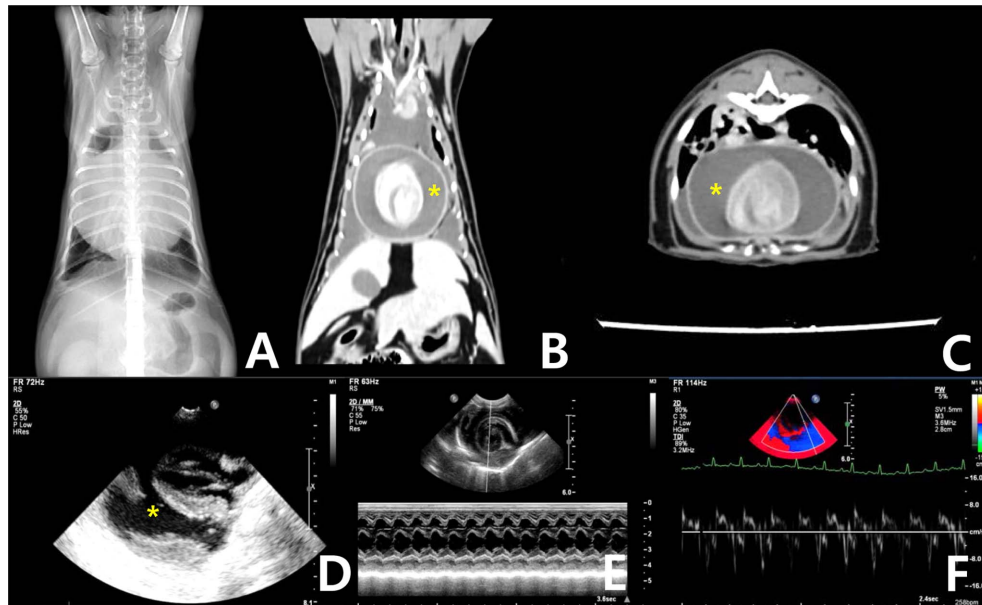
Imaging diagnosis. (A) Ventrodorsal view of the thoracic radiograph shows globoid cardiac silhouette and fissure line. (B) and (C) are thorax soft tissue window post-contrast computed tomography images (B. dorsal reconstruction image; C. transverse image) and excess fluid (yellow stars) has accumulated in the pericardial space surrounding the heart. (D), (E), and (F) show echocardiographic images. Pericardial effusion is detected and diastolic function is normal.
